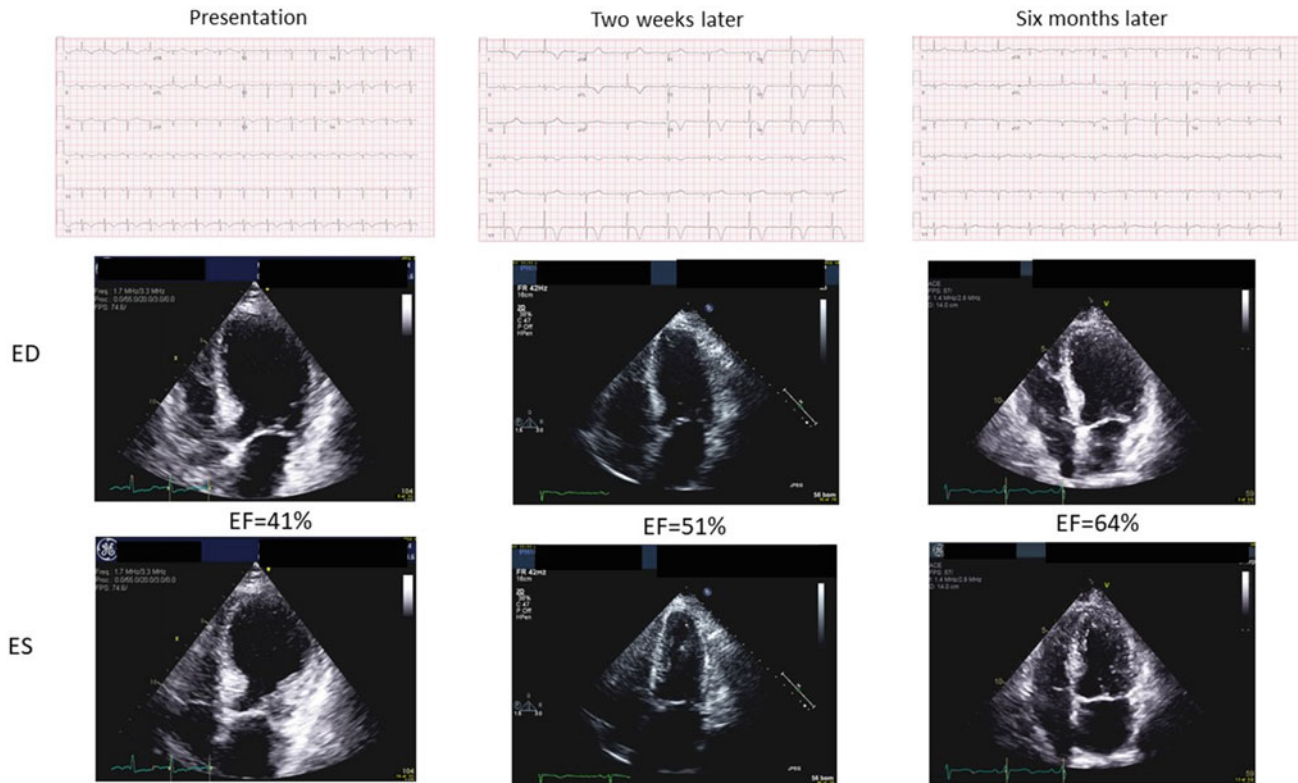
Serial EKGs, end diastolic (ED) and end systolic (ES) echo frames in a woman with bladder cancer who underwent echocardiography to evaluate for possible source of a subacute cerebral infarct discovered during workup for metastatic disease. On the initial image, the echocardiogram shows reduced EF, and characteristic apical ballooning but no left ventricular thrombus. Repeat study some two
